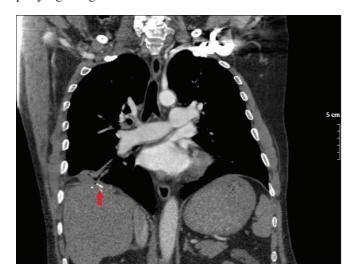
Thoracic CT demonstrating contrast material image at the level of the right diaphragm (area indicated by the arrow).
